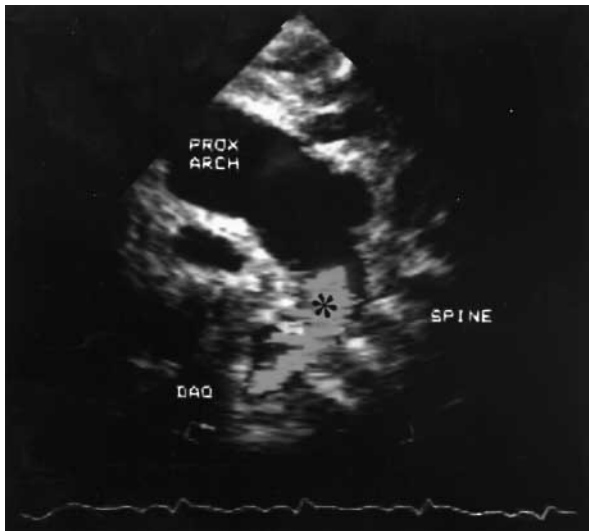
Echocardiographic image of arch reconstruction after first-stage palliation for HLHS. *Asterisk* marks the position in the descending aorta for Doppler interrogation and calculation of the DFR ratio. *DAO*, Descending aorta; *PROX ARCH*, proximal arch reconstruction.
